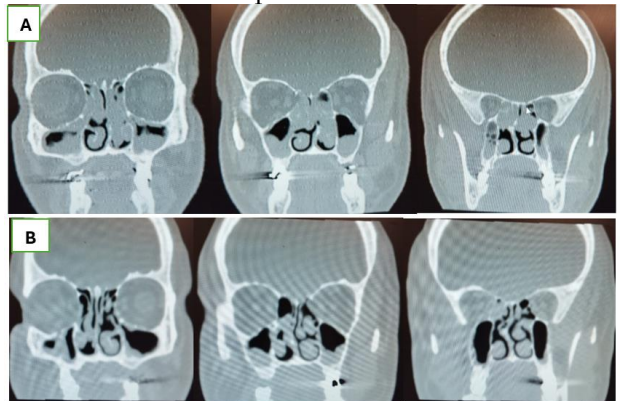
A: CT scan for a case with Lund Mackay score 23 before administration of dupilumab. B: CT scan for the same case with Lund Mackay score 7 after 6 months of administration of dupilumab
